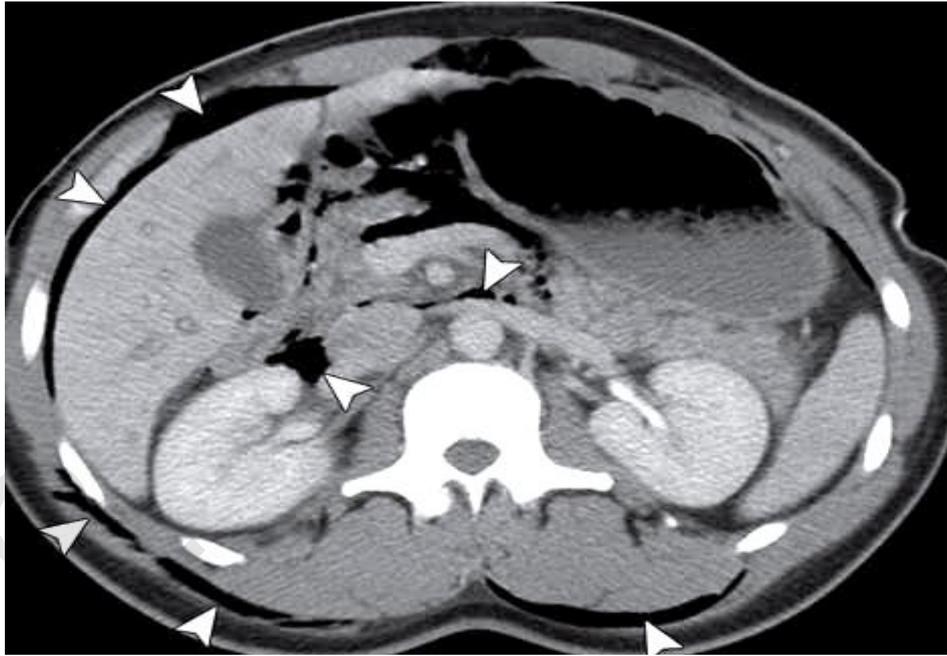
Abdominal CT scan with IV contrast (Retroperitoneal air) shows extra luminal air (arrowheads) in the right perirenal space, in the anterior pararenal space, and along the fascial planes of the abdominal musculature.
